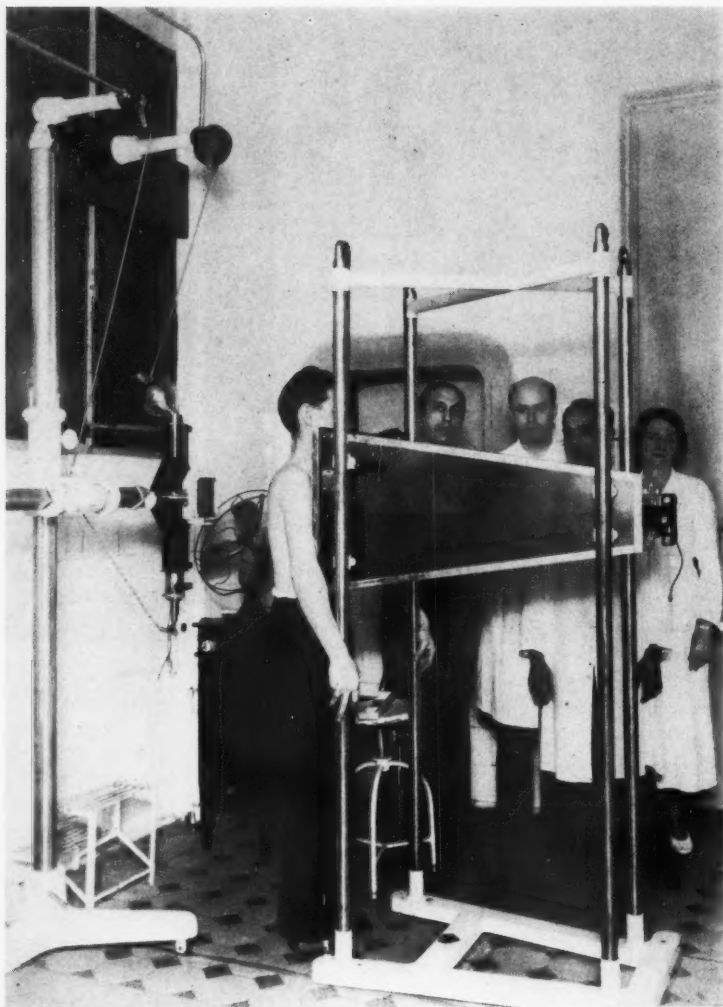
Roentgenphotographic apparatus "Manoel de Abreu" at Rio de Janeiro Public Health Department (June, 1937).
